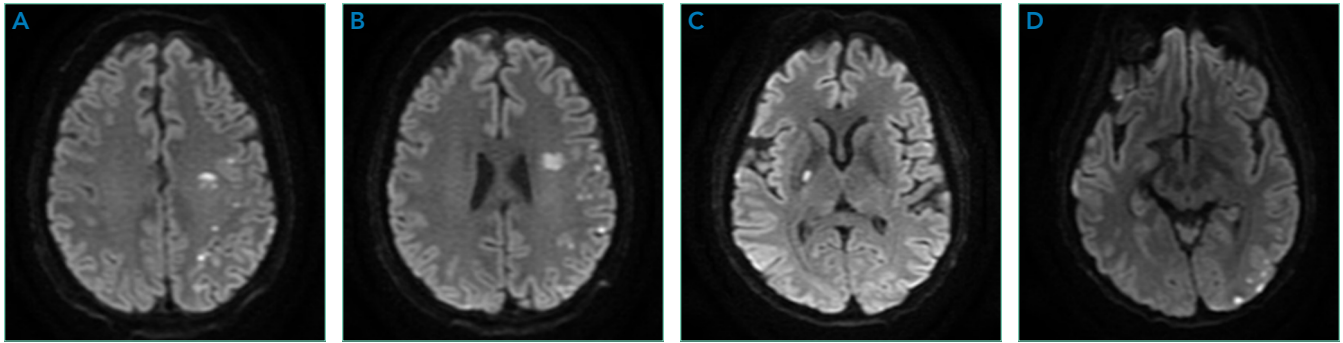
MRI images of reduced diffusion with associated fluid-attenuated inversion recovery (FLAIR) hyperintensity prominently involving the left hemisphere in left middle cerebral artery (A, B), right basal ganglia (C), and left posterior cerebral artery (D) distributions, read as numerous punctate acute infarcts involving multiple vascular territories.
